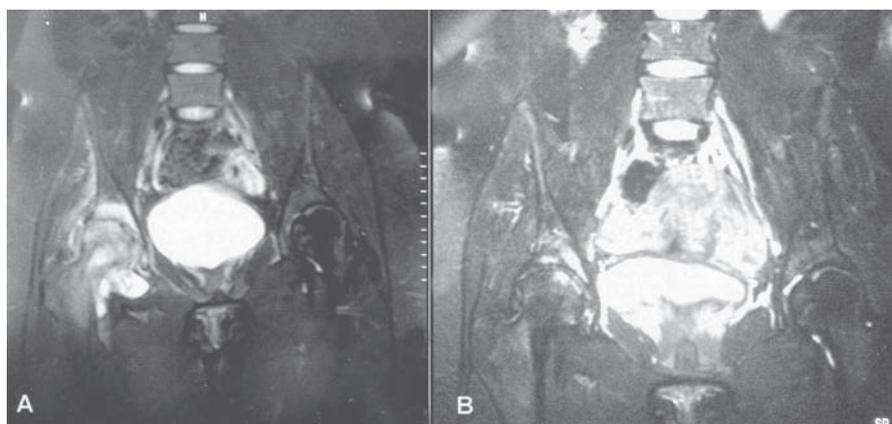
Magnetic resonance image, time T2 with fat saturation, (A) pre- and (B) post-treatment, showing injury recovery with bone edema reduction, both at femur and at acetabulum, as well as the reduction of joint edema and of the lithic area at lower neck region.
